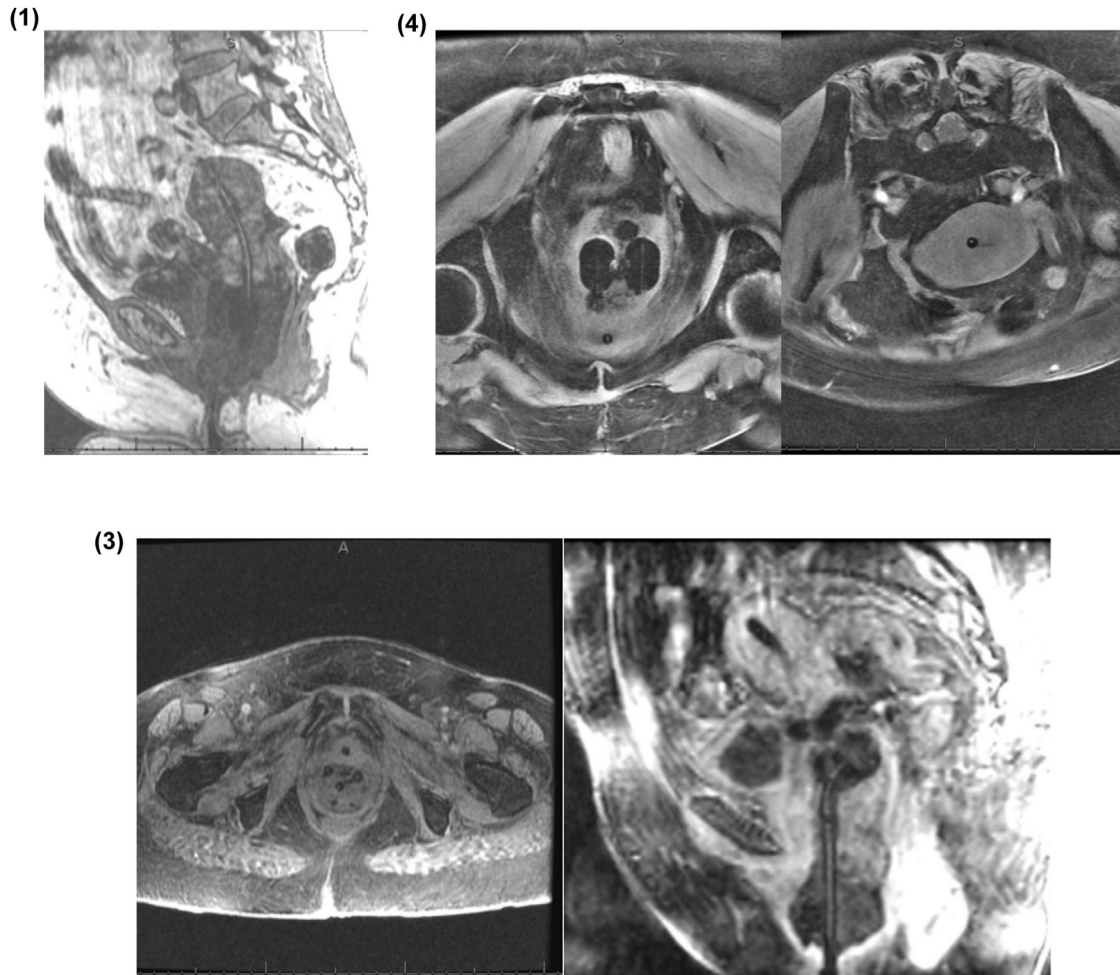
Example T1-weighted MRI images demonstrating visibility of the C4:S line markers within the gynecologic brachytherapy applicators: on 1.5-T (cases 1 and 3) and 3.0-T (case 4). Labeled by case number.
